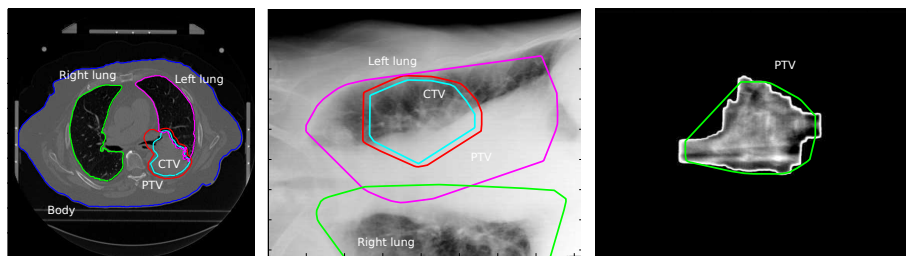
Patient image data: On the left a slice of the planning CT with the planning structures is shown, on the center the structure were projected on an X-ray acquired during treatment and on the right, only the PTV was projected on an EPID image acquired during treatment.
